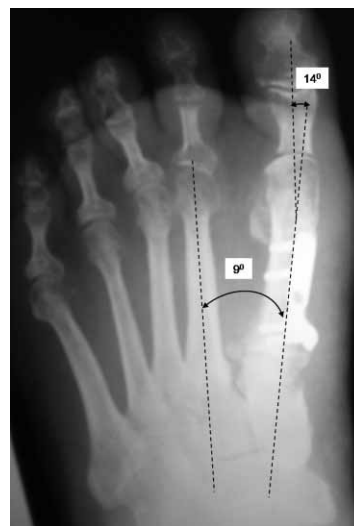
Plain radiography in full weight bearing position eight weeks after operation, show intermetatarsal angle of 9° and Hallux Valgus angle of 14° with bony union.
